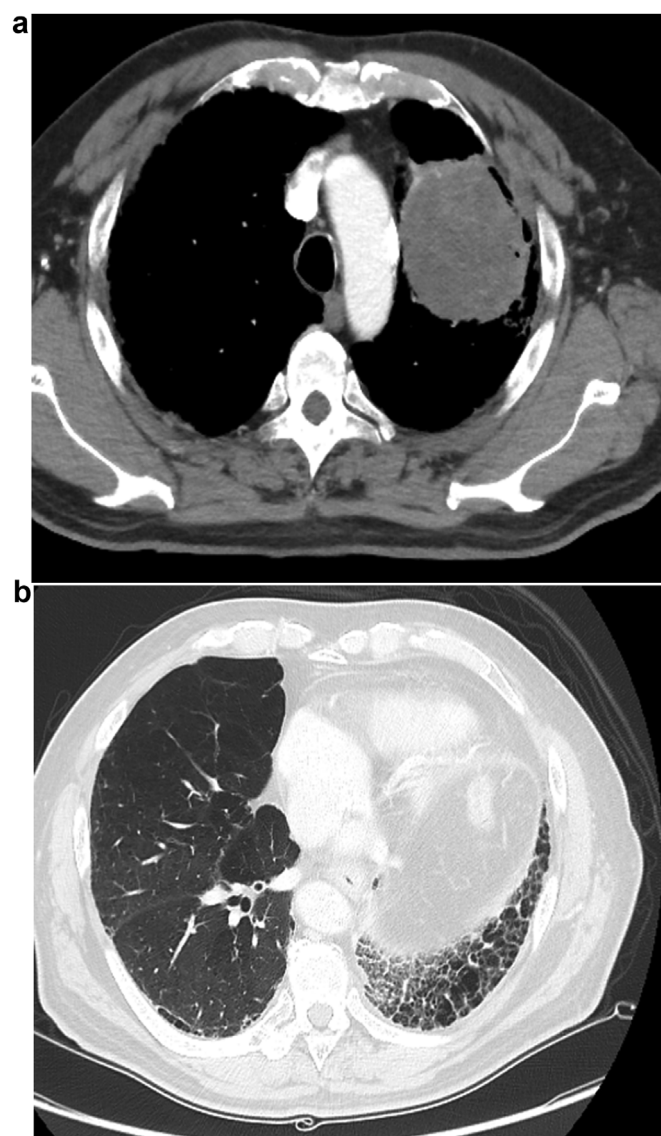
Chest computed tomography (CT) before lobectomy. It revealed a 72-mm irregularity in the upper-left lobe (A) with typical interstitial pneumonia in the inferior lobes (B).
